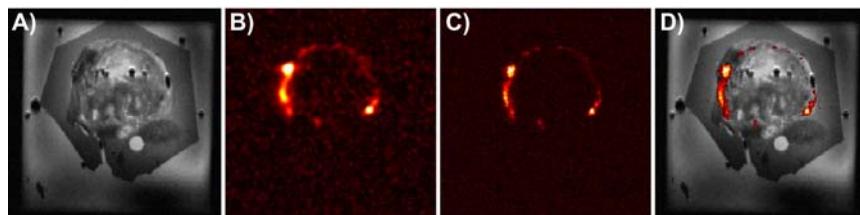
MRI results. A) ¹H Image (TE = 18ms). B) ¹⁹F MRI (low-resolved). C) ¹⁹F MRI (high-resolved). D) ¹⁹F/H overlay (high-resolved ¹⁹F MRI data).
